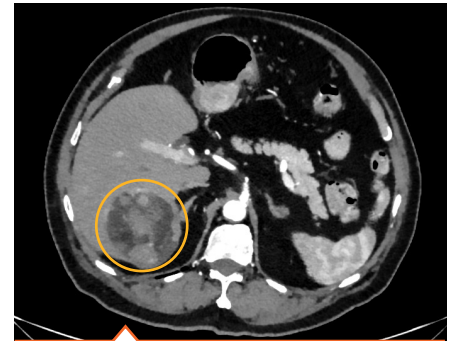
Pre-treatment CT showing 7x6 cm biopsy proven HCC in segment 6/7.
